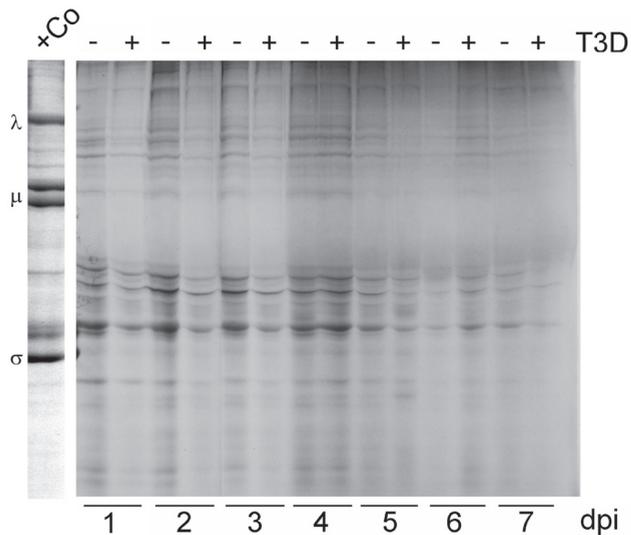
Time course of protein synthesis by 24hrs [³⁵S]-methionine-labeling experiments. Actively metabolizing tissue fragments were infected with reovirus T3D (5×10^7 pfu/fragment) on post-operative day 1 (=days post infection 0 (dpi 0)). Viral and cellular protein synthesis was tested by daily 24hrs [³⁵S]-methionine-labeling experiments until day 8 after resection (dpi 7). Lysates were prepared in sample buffer and were run out on long 45 cm SDS-polyacrylamide gels. Gels were dried and exposed to radiographic film. The positive control HCT116 (+Co) demonstrates the λ , μ and σ reoviral proteins. T3D; reovirus T3D.
